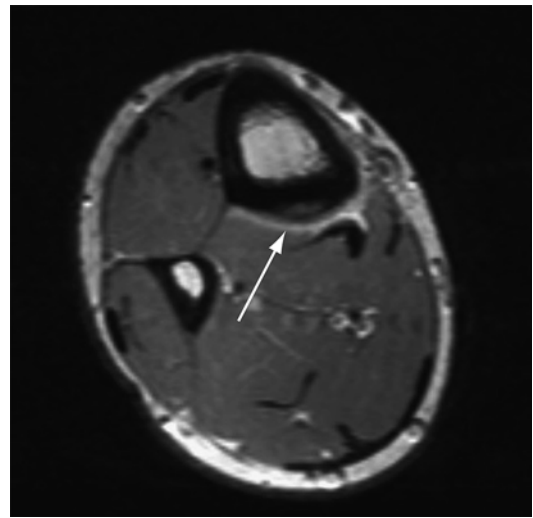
MR of chronic stress reaction. Axial proton-density MR image shows periosteal elevation in the posterior cortex of the tibia (*arrow*) and adjacent inflammation
